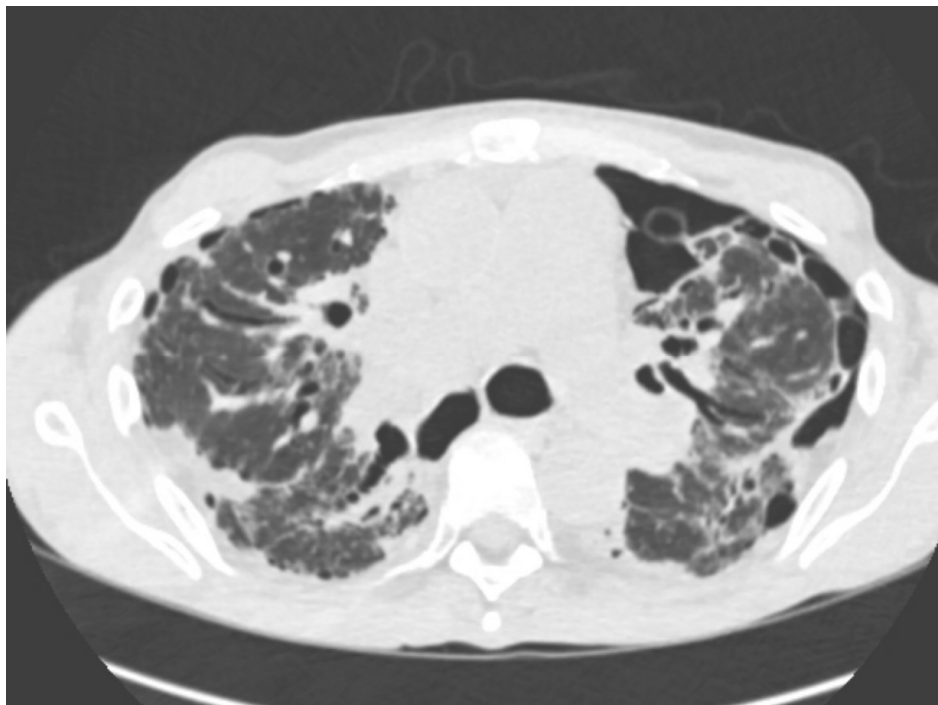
CT scan of the patient, showing fibrosis, bullae and a pneumothorax.
